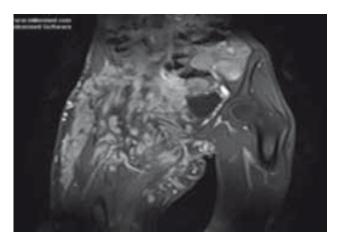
Mycetoma MRI showing features of mycetoma
